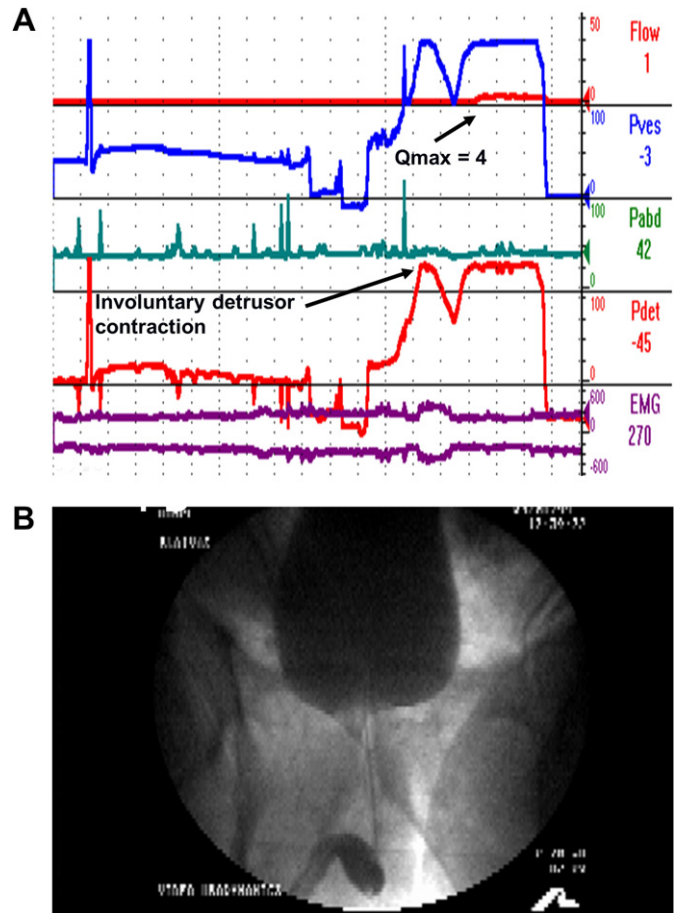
Schafer grade 6 obstruction and type 3 overactive bladder (OAB) in a 56-year-old man with a 10-year history of severe OAB and obstructive symptoms treated with doxazosin and finasteride, AUASS = 27. A. Urodynamic tracing. He had an involuntary detrusor contraction at a bladder volume of 175 mL and was able to temporarily prevent incontinence by contracting his sphincter, but was unable to abort the detrusor contraction and finally voided involuntarily with a sustained detrusor contraction. $P_{det@Q_{max}} = 135$ cmH₂O; $Q_{max} = 4$ mL/s, BOOI = 127. The sudden fall in vesical pressure (pves) and a negative detrusor pressure at maximum flow (pdet) were artifacts caused by the catheter moving into the urethra. It was replaced, and the pressure recording was accurate again. B. X-ray obtained at Q_{max} showing a diffusely narrowed prostatic urethra. He underwent a suprapubic prostatectomy (350 g prostate), and his urinary frequency decreased from 18 to eight voids per day, his urgency subsided, maximum voided volume increased from 120 to 240 mL, Q_{max} increased from 4 to 17 mL/s, and the post-void residual decreased from 68 to 8 mL.
